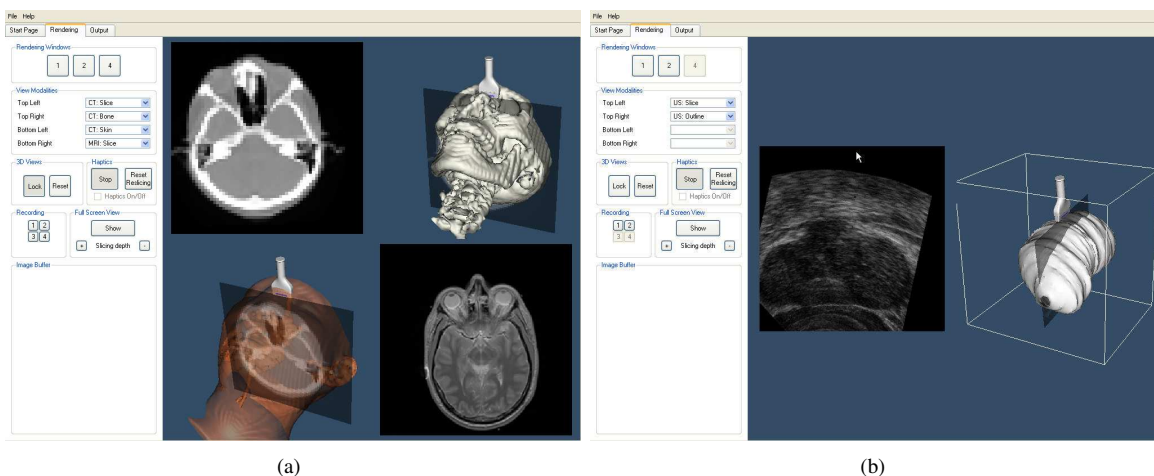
(a) Real-time MRI/CT re-examination of Visible Human dataset and (b) Real-time ultrasound re-examination of prostate.
